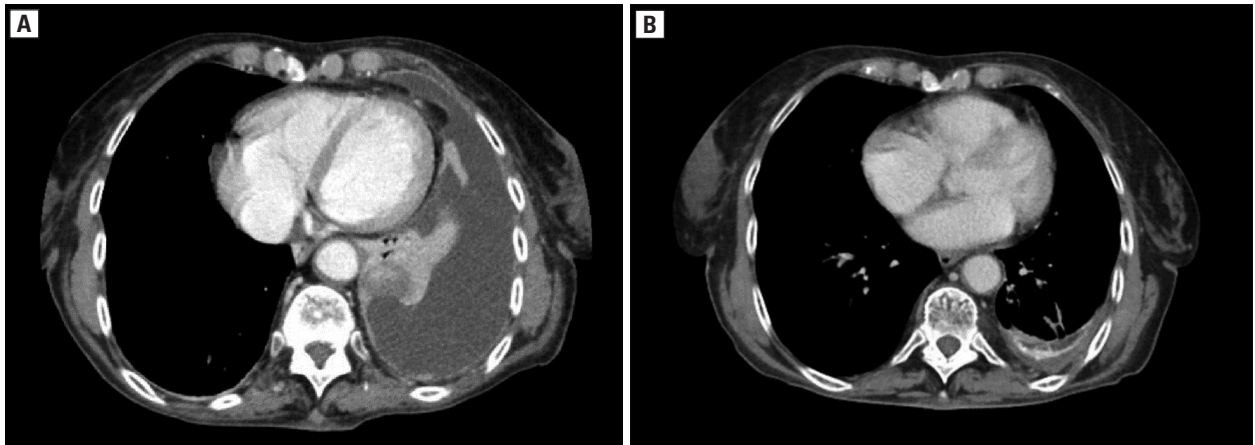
A. Imaging at the time of diagnosis. CT scan showing tumor (3 x 2 cm) in the left lower lobe, with pleural nodules and massive pleural effusion; B. Imaging after six months of treatment. CT scan showing complete remission and post-pleurodesis lesions
